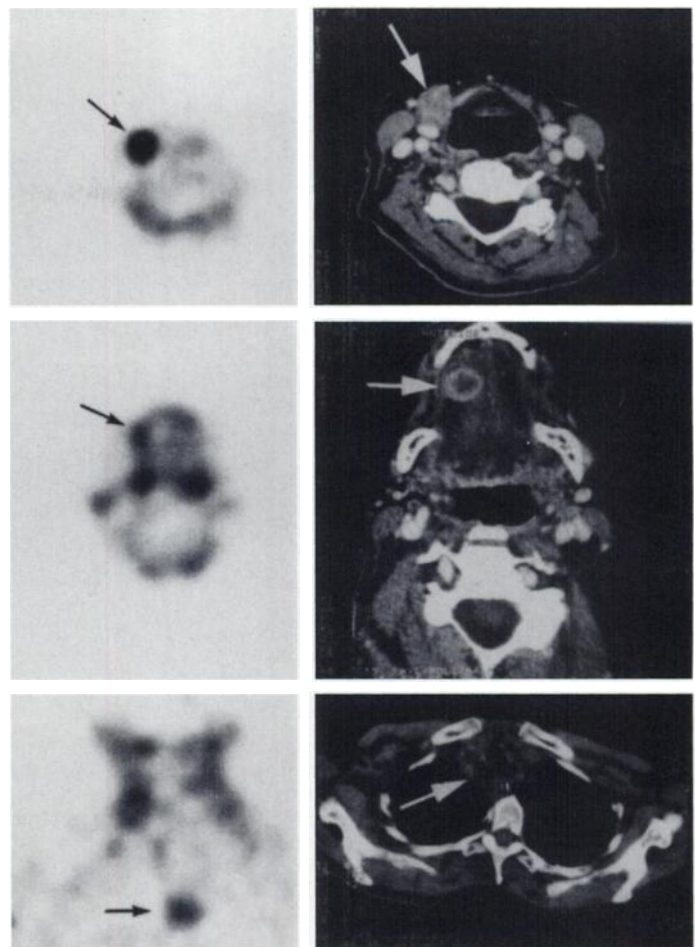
Transaxial ^{201}Tl SPECT images (left) and enhanced CT (right) of a patient presenting with metastases in the neck and tongue. SPECT findings (black arrows on top and middle images) match those of CT (white arrows), showing intense uptake in the lymph node metastasis but discreet accumulation in the tongue metastasis that is characterized by necrotic changes. Primary tumor was localized in the esophagus by coronal SPECT images and subsequently by CT (bottom).
